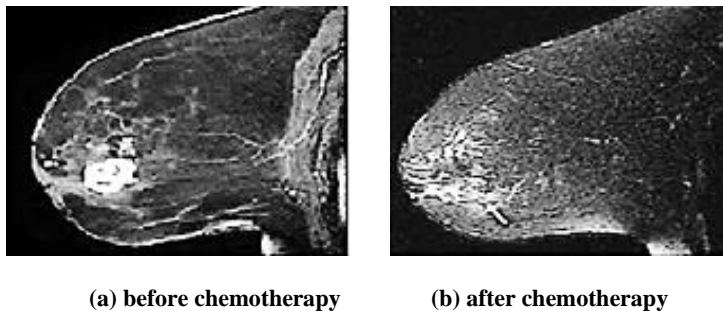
MRI breast cancer images before and after chemotherapy [22].
